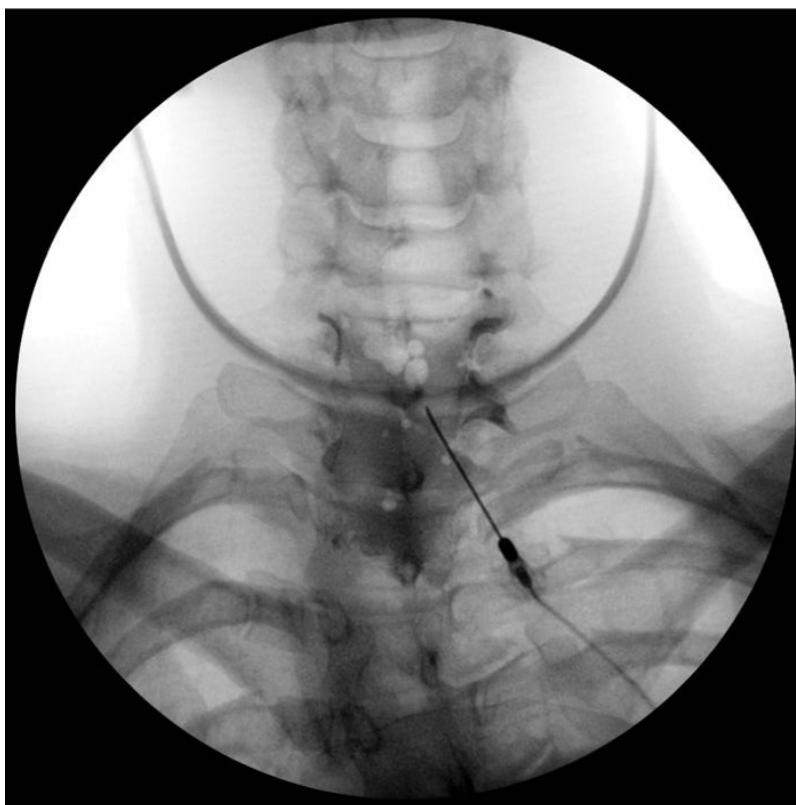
Fluoroscopic image with higher density structures appearing darker; note the bubbles of air contained within the injected x-ray contrast medium.
